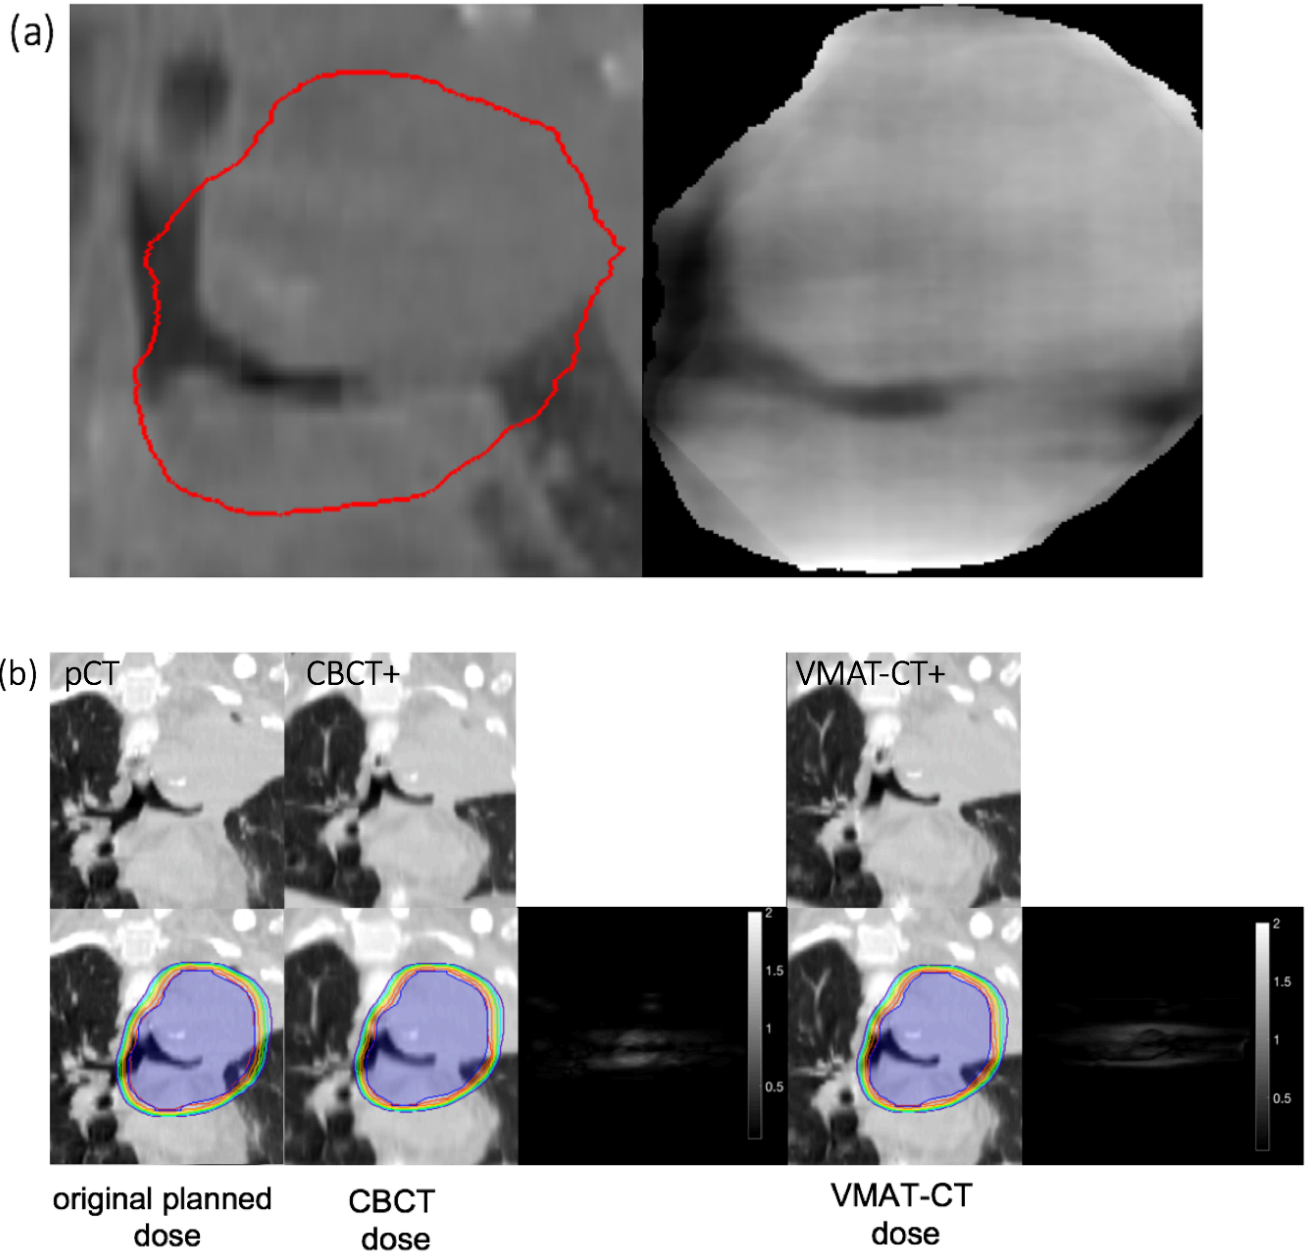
Dose comparisons on patient. (a) Comparison of CBCT with VMAT-CT. (b) (Top row) comparison of original planning CT (pCT), CBCT+ (pCT registered to pre-treatment CBCT), VMAT-CT+; (bottom row) dose distributions in original plan, dose based on pre-treatment CBCT, and 3D Gamma plot of comparison between CBCT dose and original planned dose, dose based on in-treatment VMAT-CT+, 3D Gamma plot of comparison between VMAT-CT dose and original planned dose. The blue shaded area is the original and deformed PTV contour.
